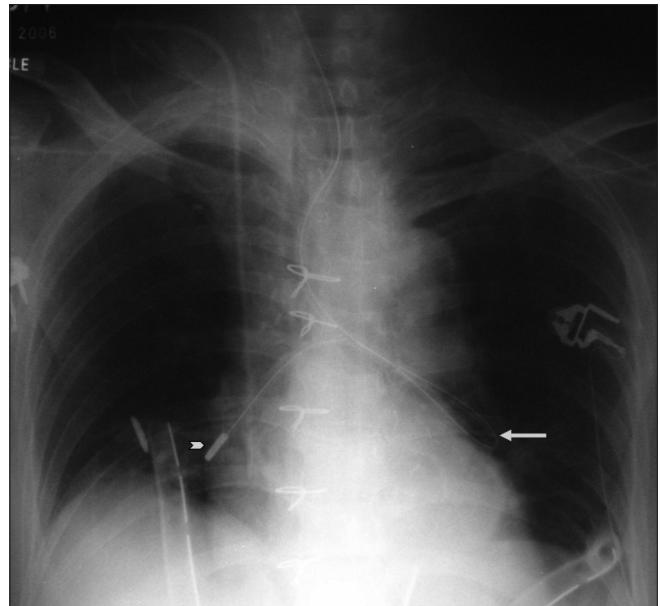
Frontal radiograph of the chest shows a NG tube forming a loop in the left bronchus (arrow) before the tip (arrowhead) reaches the right lower lobe bronchus
